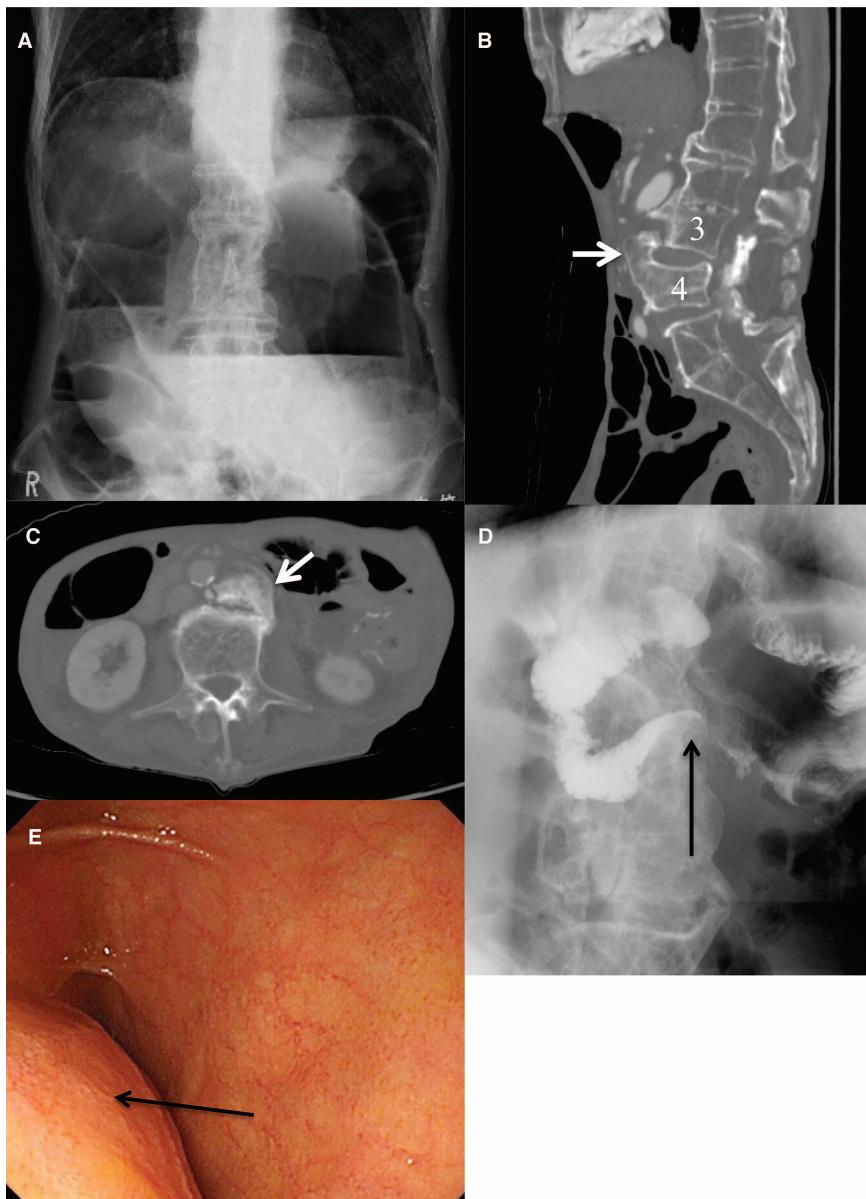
A, Abdominal radiograph showing marked distention of the interposed jejunum. B, C, A computed tomography scan showed large anterior osteophytes at L3/4 and L4/5, displacing the aorta anteriorly. Numbers 3 and 4 indicate the levels of the lumbar spine. Arrows indicate the osteophytes. D, Gastrografin administration showed the accumulation of contrast in the third part of duodenum with proximal dilation and slow passage into the distal small bowel. The arrow indicates the narrowed area. E, Esophagogastroduodenoscopy showed the external obstruction at the center of a third part of the duodenum. Arrow showing elevated duodenum from the outside.
